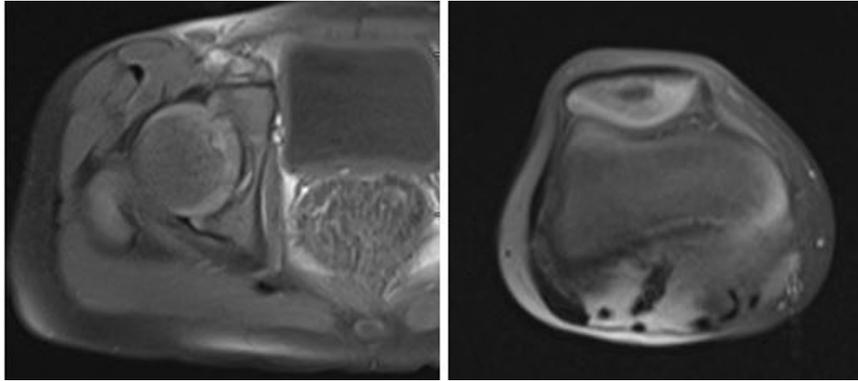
Axial T1 magnetic resonance imaging scan of the right hip and knee.
